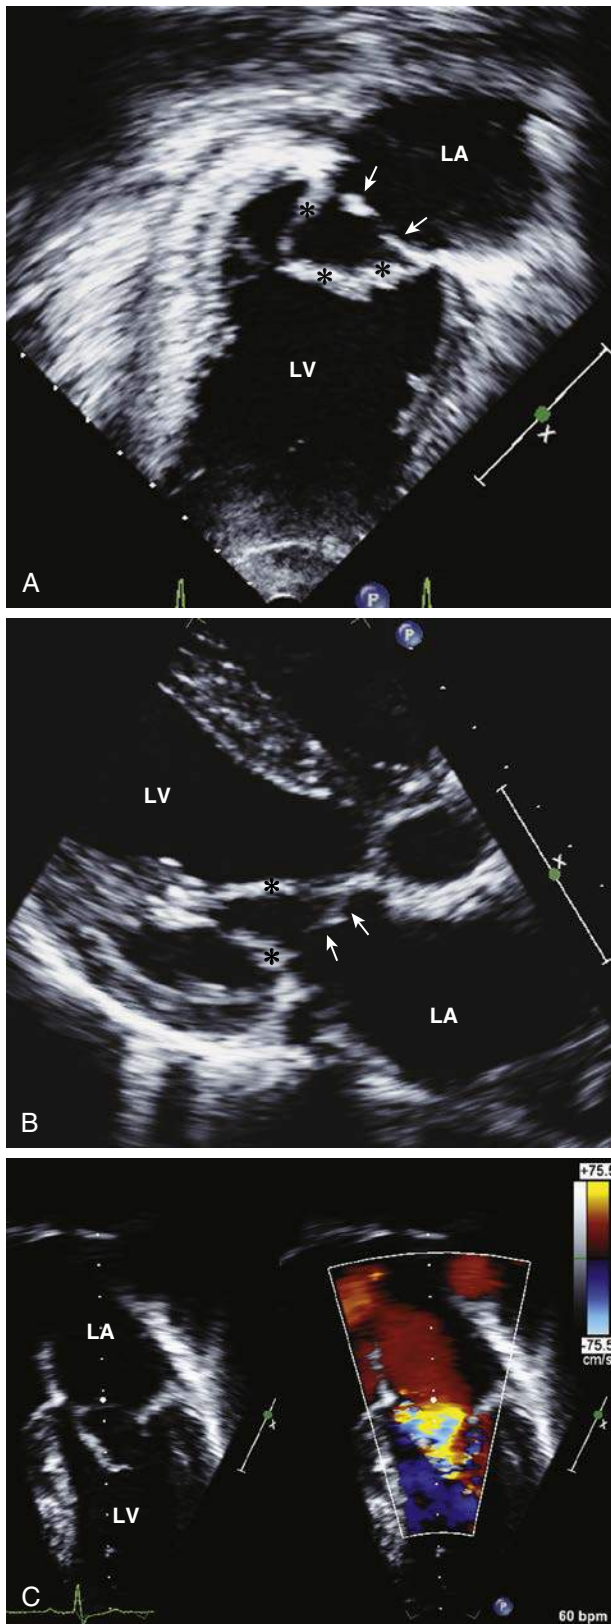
Transthoracic echocardiography imaging of a supramitral ring. A, Apical two-chamber view of supramitral ring during diastole. B, Parasternal long-axis view of a supramitral ring during diastole. C, Apical four-chamber view of a supramitral ring during diastole. The attachment of the membrane to the left atrial aspect of the mitral valve is apparent. Color Doppler (*right image*) demonstrates flow acceleration at the level of the supramitral membrane. *White arrows*: supramitral ring; *black asterisk*: mitral valve. LA, Left atrium; LV, left ventricle.
